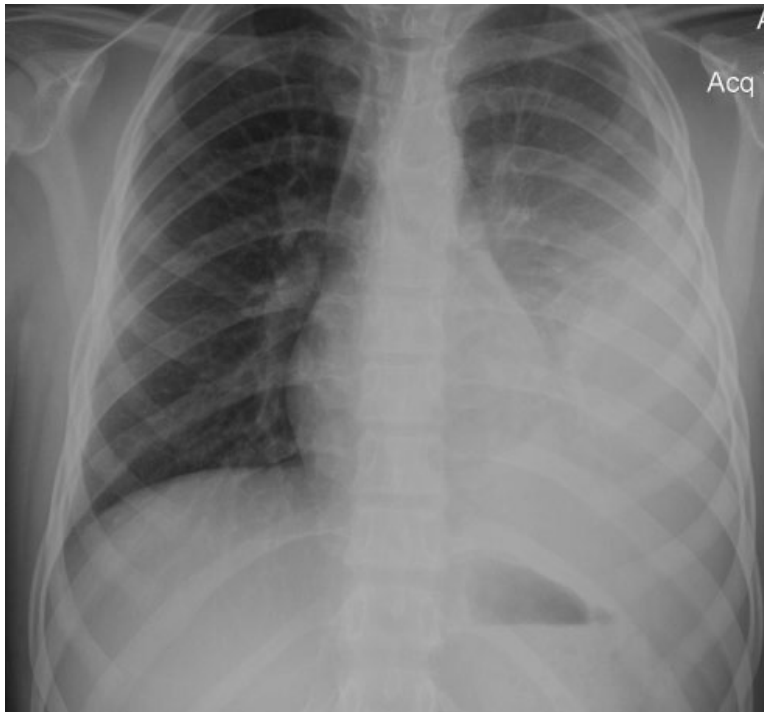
Chest X-ray showing a tuberculous pleural effusion in a teenage boy.
